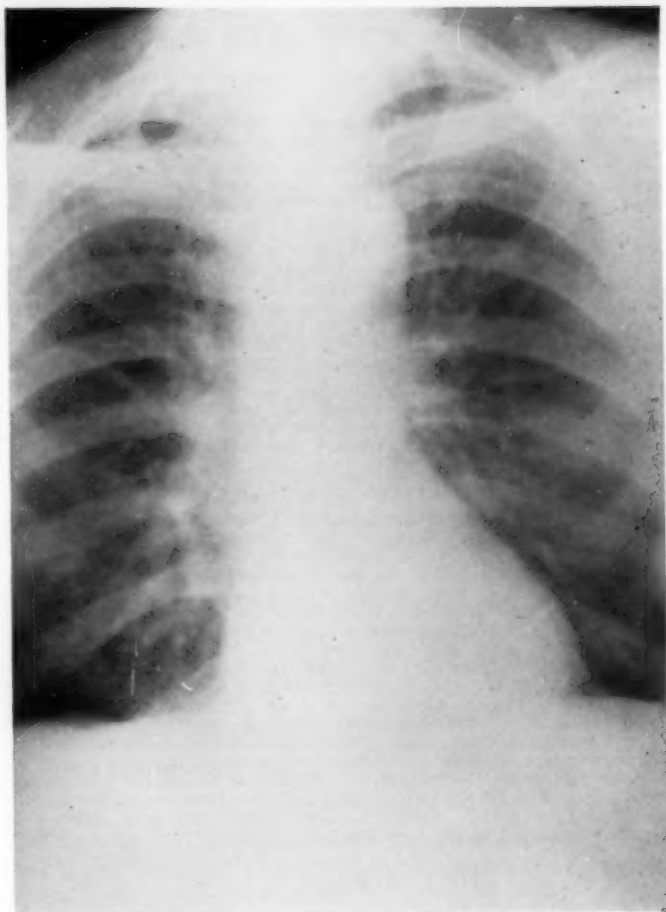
Posteroanterior roentgenogram of the chest reveals slight generalized pulmonary edema with some prominence of the bronchovascular markings.
